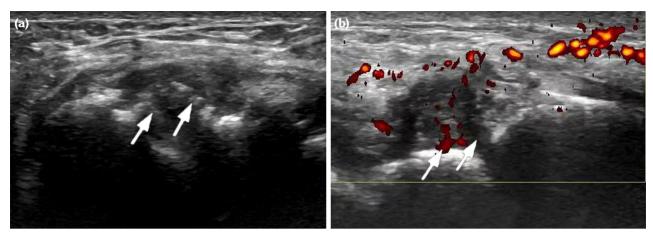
Two-dimensional and energy Doppler ultrasound images of SPRA bone erosion. A 54-year-old woman diagnosed with SPRA; ultrasound images of right wrist: (a) Showing scaphoid proximal pole resorption and insect-like bone erosion (indicated by the arrow); (b) synovial hyperplasia in the wrist cavity with Grade 2-3 and a synovial blood signal Level of 2 (indicated by the arrow).
